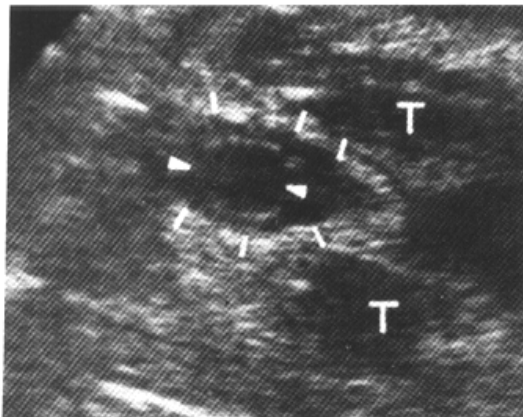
Transverse sonogram of the fetal perineum. Notice the hypoechoic cystic space (arrowheads) spreading the labia majora (lines). T, thigh. (Reproduced with permission from Davis et al: *J Ultrasound Med* 3:371, 1984.)
